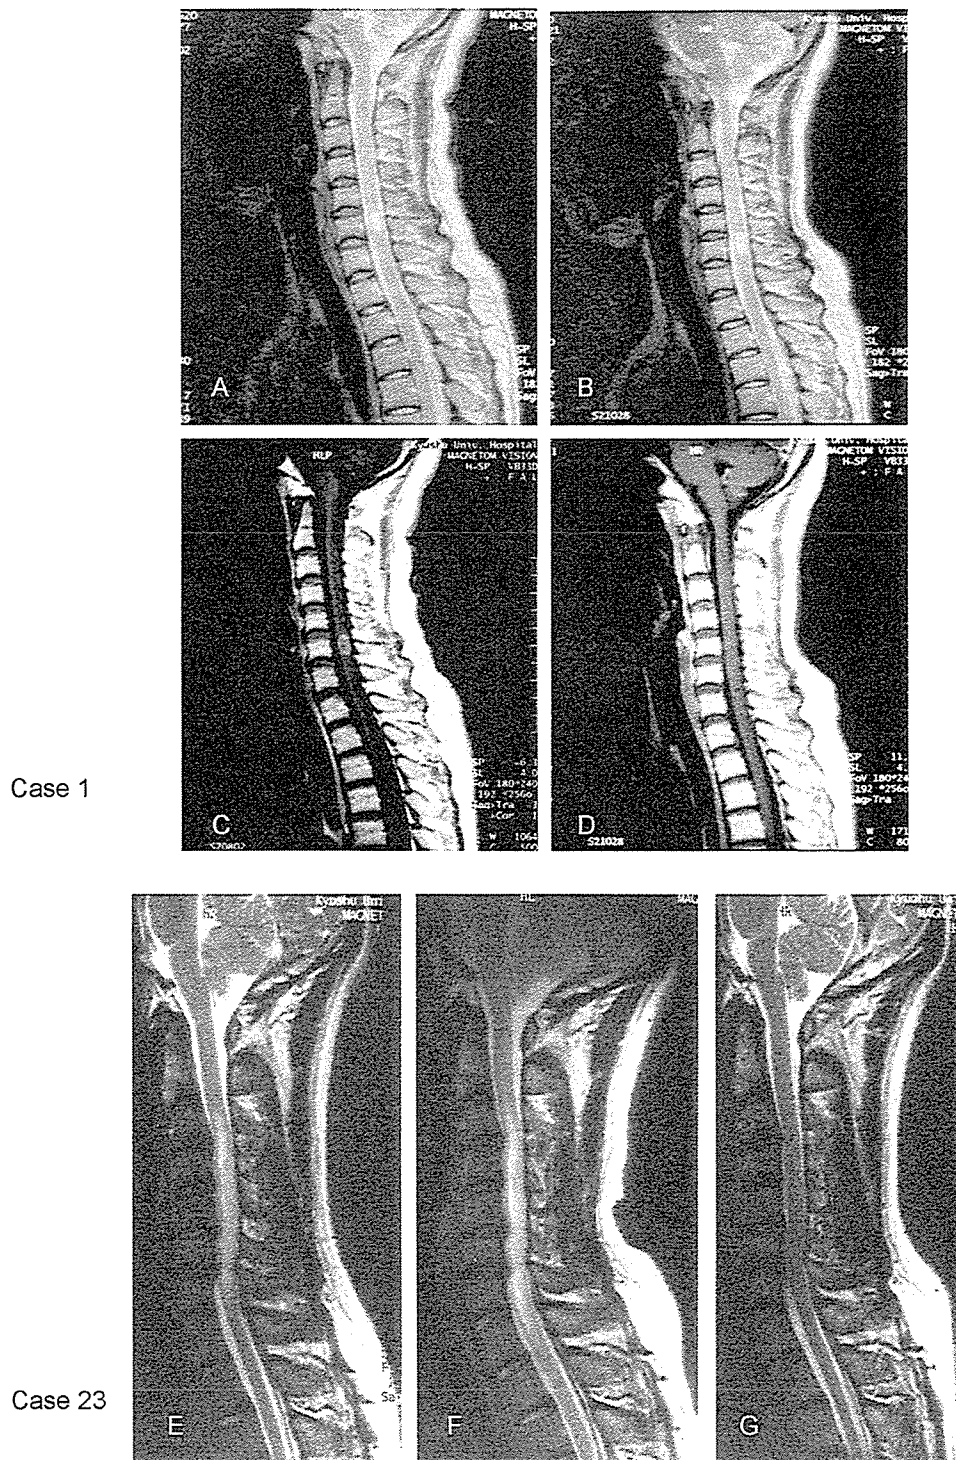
Representative cases showing improvement on MRI. Case 1: (A) T2-weighted MRI before PE; (B) T2-weighted MRI after PE; (C) T1-weighted MRI with gadolinium enhancement before PE; and (D) T1-weighted MRI with gadolinium enhancement after PE. A T2-high intensity lesion is located at the C6 spine level and is enhanced by gadolinium. After the PE treatment, the enhancement has disappeared although the T2-high intensity lesion is unchanged. Case 23: (E) T2-weighted MRI before CS; (F) T2-weighted MRI after CS and before PE; and (G) T2-weighted MRI after PE. A T2-high lesion is seen at the C3-7 spine levels. After the treatment with CS, the lesion is not improved, but it disappears after performing PE.
